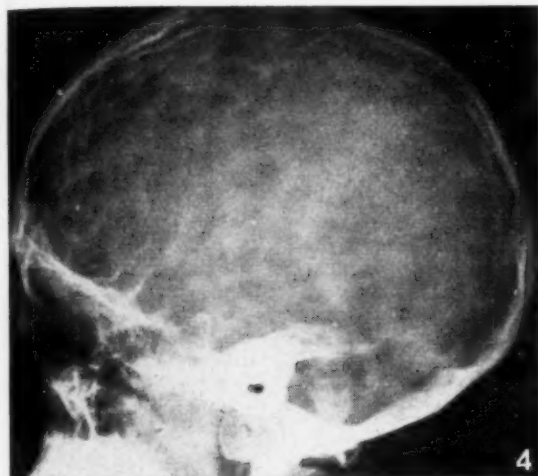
Lateral radiograph of skull. Numerous convolutional markings. Floor of middle and anterior fossae shortened.
